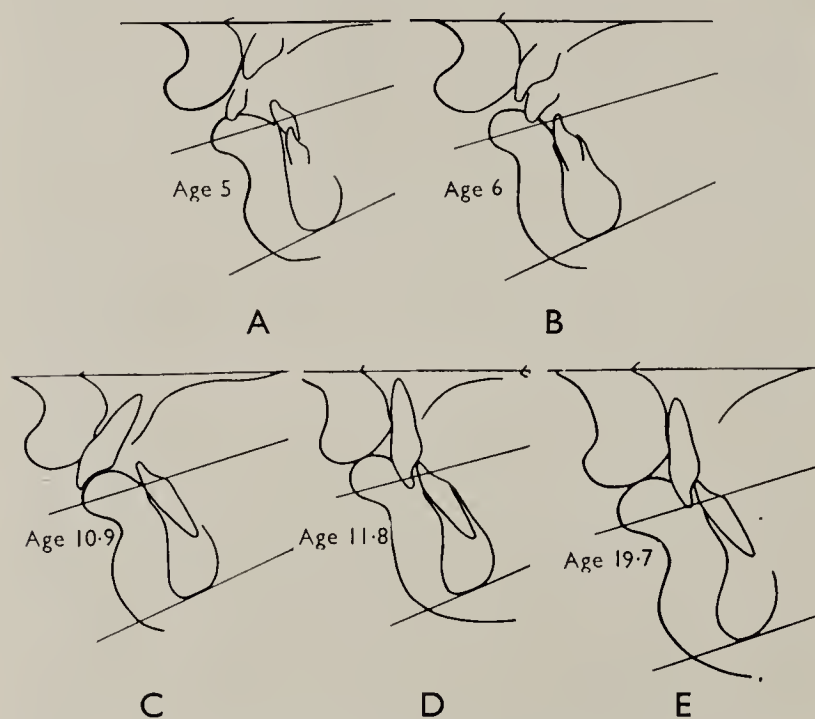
Tracings from serial skull radiographs of one individual showing development of a Class II, division 1 incisor relationship determined by lip morphology and relationship, and the constancy of the relationship of occlusal line to lower lip profile.
